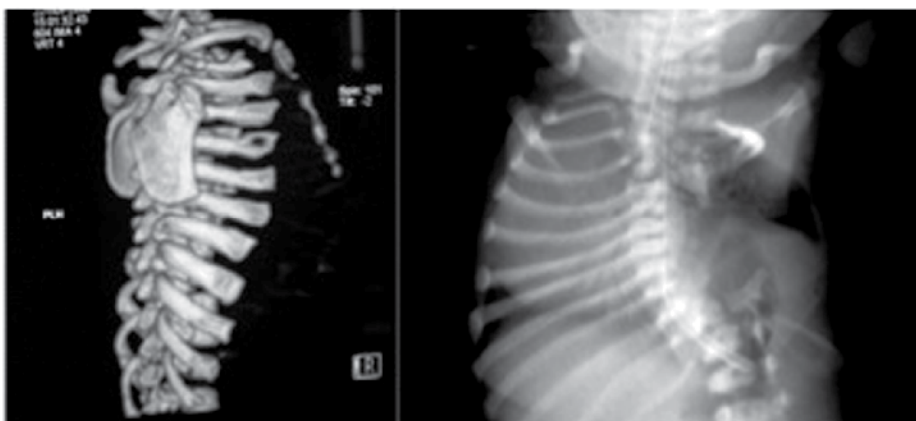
Left:* Jeune syndrome (Asphyxiating thoracic dystrophy), type severe. Computerized Tomography reconstruction of the rib cage shows the typical ribs of Jeune syndrome; *Right:* Cerebrocostomandibular syndrome. Unilateral agenesis of thoracic cage shown at thoracic X-Ray
